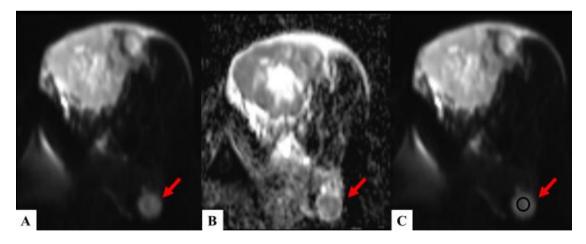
DWI & ADC sequences of axillary lymph node in a patient with infiltrative ductal carcinoma in left breast:
